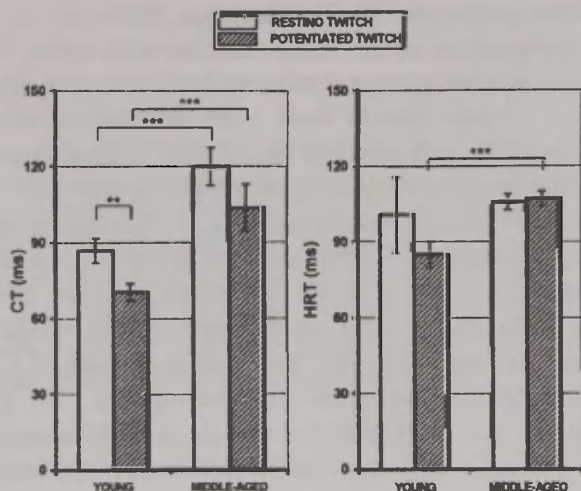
Mean ( $\pm$  SEM) values of twitch contraction time (CT, *left*) and half-relaxation time (HRT, *right*) in young and middle-aged men.
